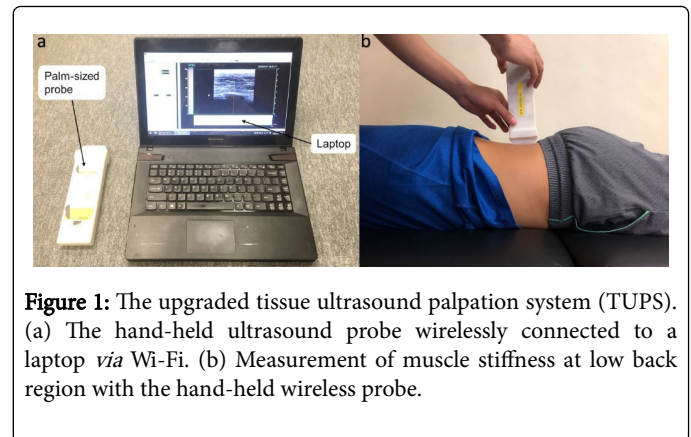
The upgraded tissue ultrasound palpation system (TUPS). (a) The hand-held ultrasound probe wirelessly connected to a laptop *via* Wi-Fi. (b) Measurement of muscle stiffness at low back region with the hand-held wireless probe.
